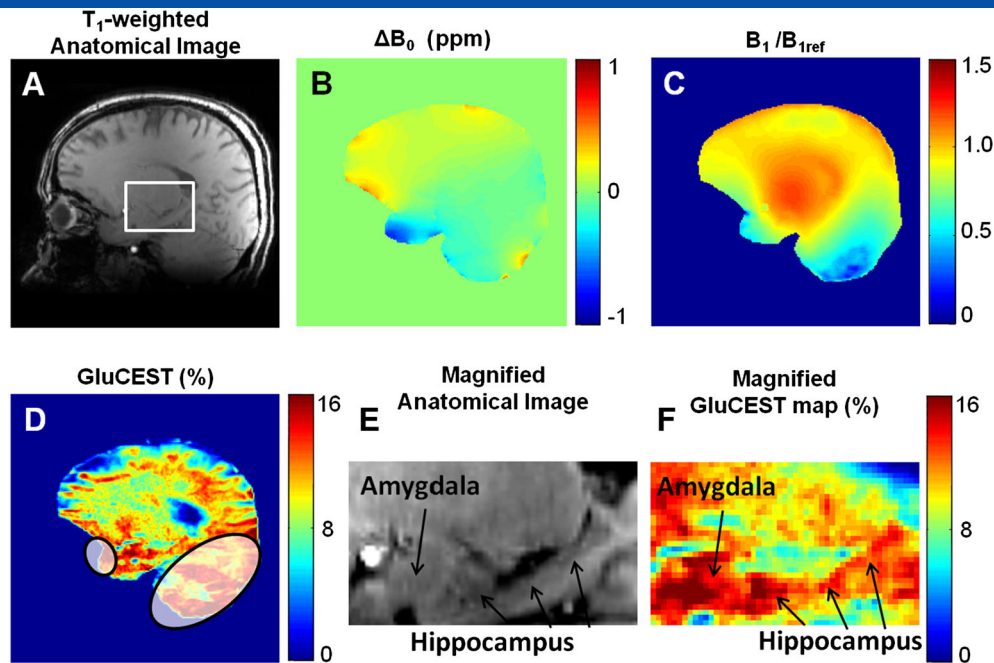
A representative GluCEST map from a sagittal brain slice. Representative MRI data from sagittal brain slice. A, Proton anatomic image showing amygdala and hippocampus in the white box. B, ΔB_0 map; C, B_1 map; D, GluCEST map of the same slice. Two regions marked with ovals have less than 50% B_1 that cannot be fully corrected for B_1 inhomogeneity. E, F, A 15 times magnification of the proton image and CEST map from the amygdala and hippocampus region (white square in A).
